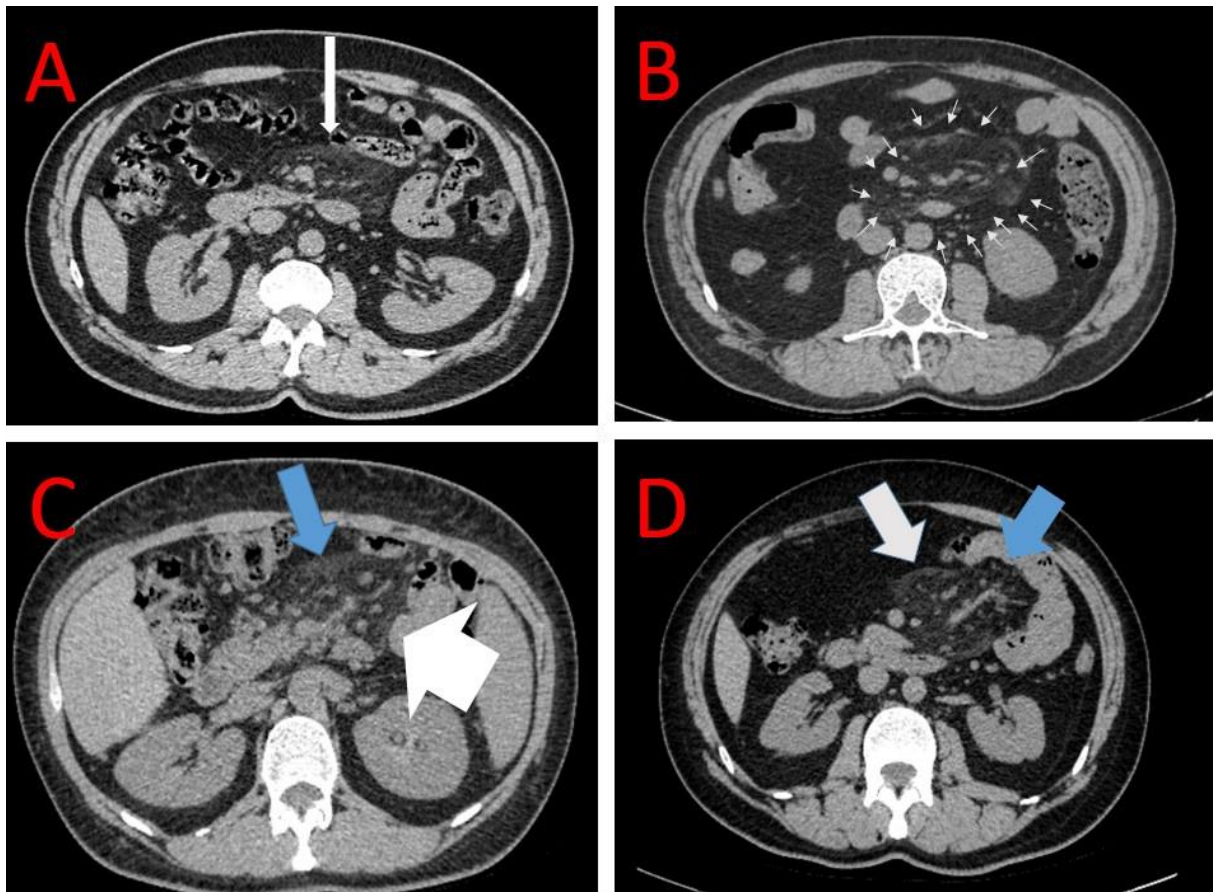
A. Misty mesentery view on axial CT sections (white arrow). B. Misty mesentery appearance and surrounding pseudo capsule (small white arrows) on axial CT scans. C. Significant heterogeneity, thickening (blue arrow), and fat ring sign (white arrow) in mesenteric fatty planes on axial CT scans. D. Heterogeneity, thickening, inflammation findings (white arrow), and millimetric nodules (blue arrow) in mesenteric fatty tissue in axial CT sections.
